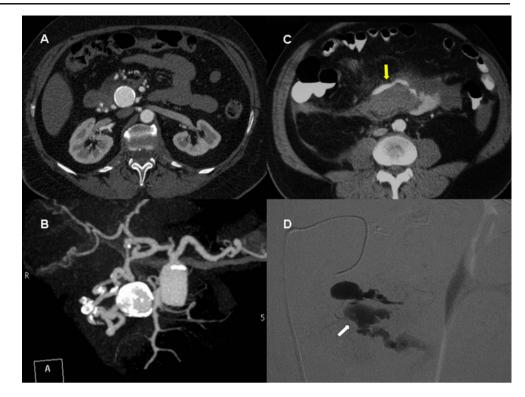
Gastroduodenal artery pseudoaneurysm rupture. a, b An enhancing pancreaticoduodenal pseudoaneurysm with mural calcifications in an axial enhanced CT and 3D reconstruction. c, d. Enhanced CT scan showing a point of active bleeding (*yellow arrow*) from gastroduodenal artery. IV Contrast pools in the left retroperitoneum (*white arrow*)
